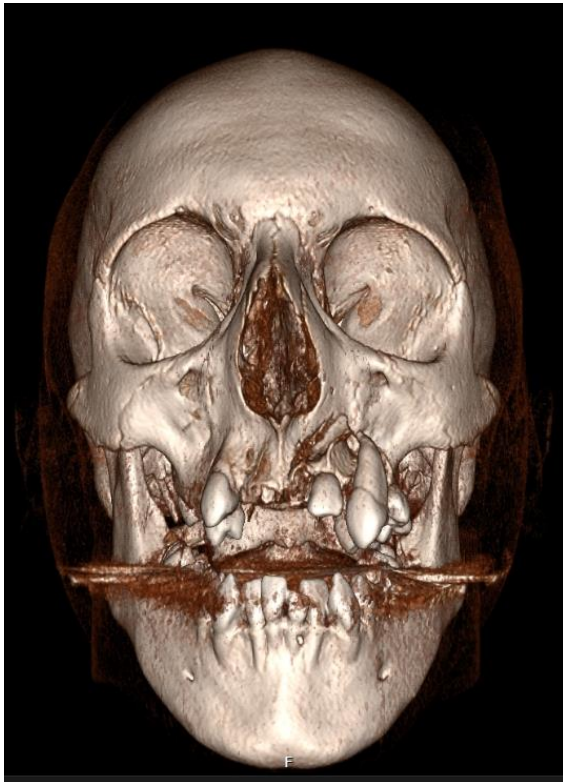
(A-B) – 3D reconstruction of CT head taken on the day of injury showing complex, comminuted, displaced left maxilla fracture involving alveolar process with displaced teeth. Fracture complex involves left upper teeth up to and including UL6. UR6 UR5 UR2 UR1 UL1 are missing. UL2 is angulated horizontally. UL3 is buccally luxated out of the buccal plate.
